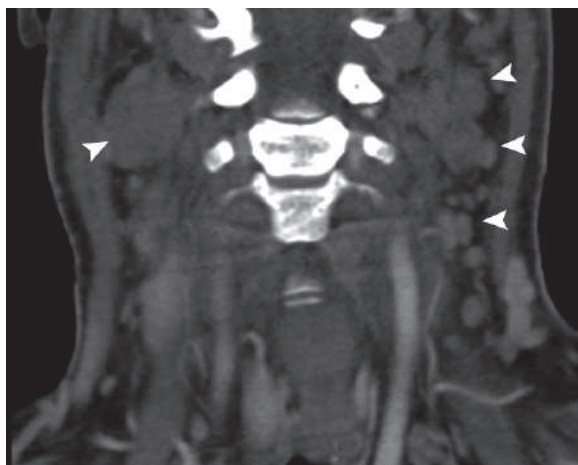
Coronal postcontrast neck CT of a patient with neck choloroma shows bilateral lymphadenopathy (arrowheads)
